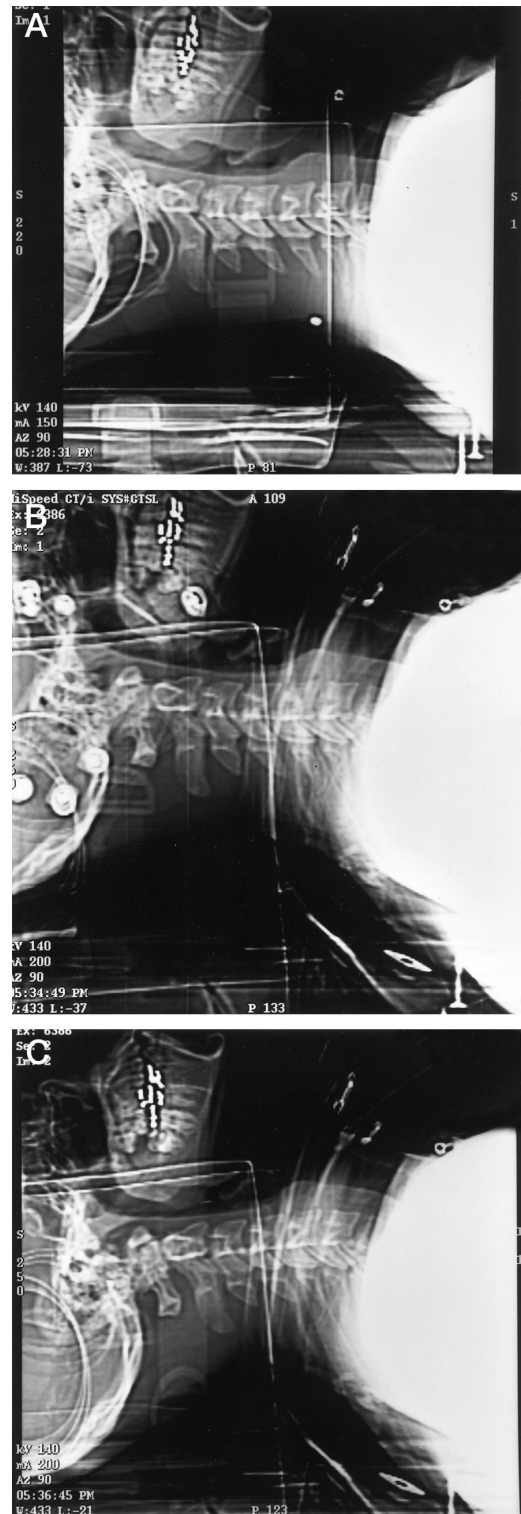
Demonstration of the lateral CT scans of the cervical spine in a 20-year-old man immobilized to a backboard. A, no protective equipment (control). B, wearing an ice hockey helmet and shoulder pads. A minimal change in cervical alignment occurs compared with the control. C, wearing only shoulder pads (helmet removed). An increase of lordosis occurs in overall subaxial cervical spine alignment.
